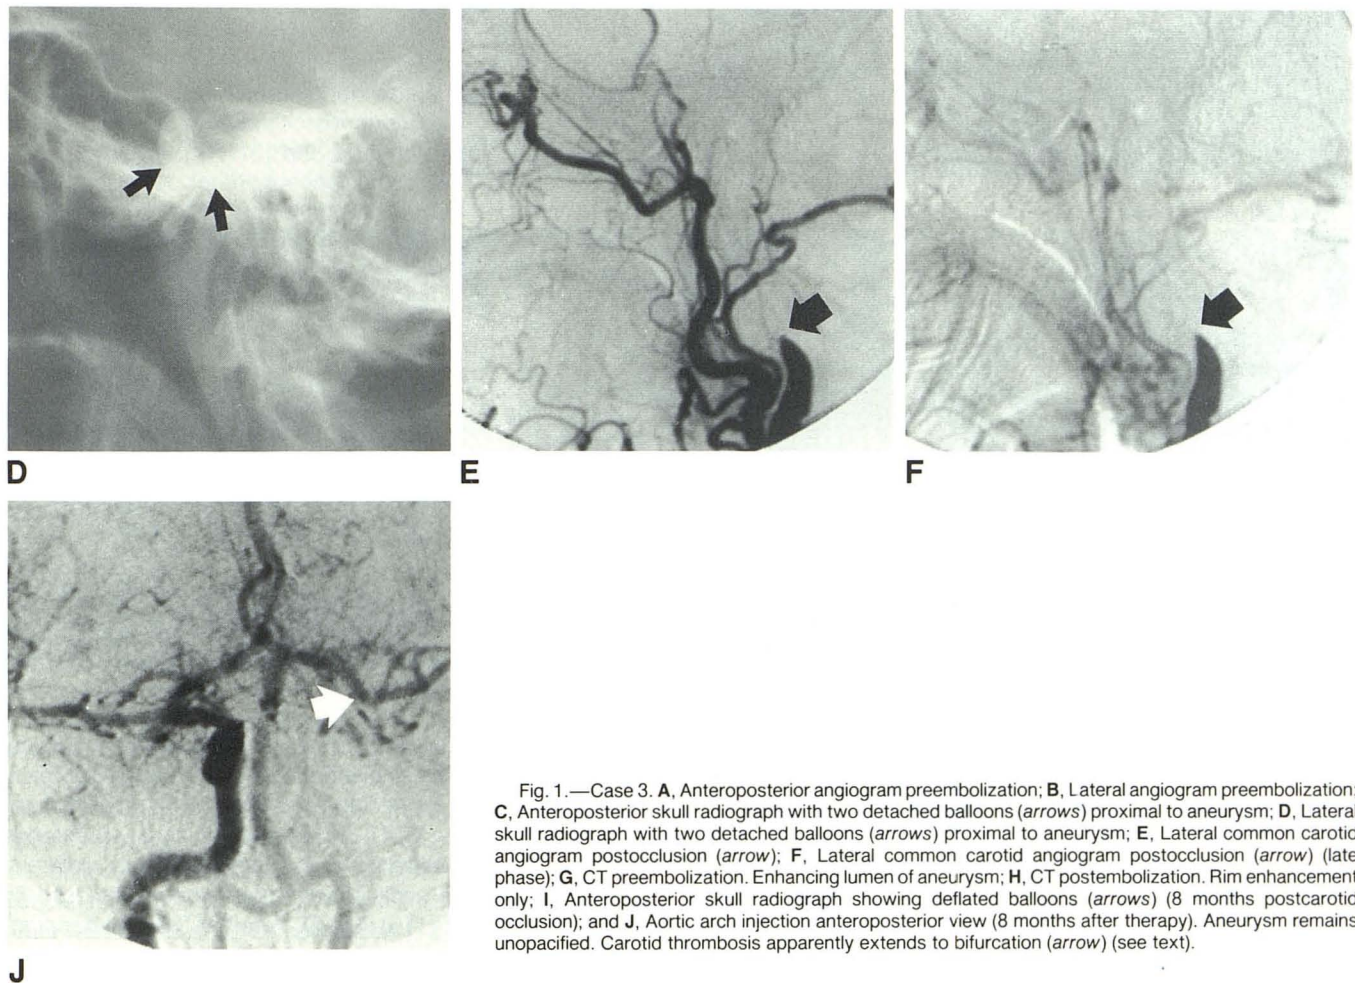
Case 3. A, Anteroposterior angiogram preembolization; B, Lateral angiogram preembolization; C, Anteroposterior skull radiograph with two detached balloons (arrows) proximal to aneurysm; D, Lateral skull radiograph with two detached balloons (arrows) proximal to aneurysm; E, Lateral common carotid angiogram postocclusion (arrow); F, Lateral common carotid angiogram postocclusion (arrow) (late phase); G, CT preembolization. Enhancing lumen of aneurysm; H, CT postembolization. Rim enhancement only; I, Anteroposterior skull radiograph showing deflated balloons (arrows) (8 months postcarotid occlusion); and J, Aortic arch injection anteroposterior view (8 months after therapy). Aneurysm remains unopacified. Carotid thrombosis apparently extends to bifurcation (arrow) (see text).
